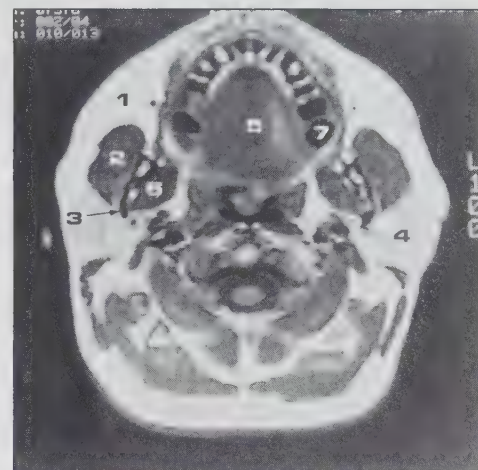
Axial T1 weighted MRI at level of maxillary alveolus: (1) subcutaneous fat (high intensity); (2) masseter muscle (medium intensity); (3) cortical bone of ramus (low intensity); (4) parotid gland (medium to high intensity); (5) hard palate; (6) medial pterygoid muscle; (7) maxillary second molar root.
